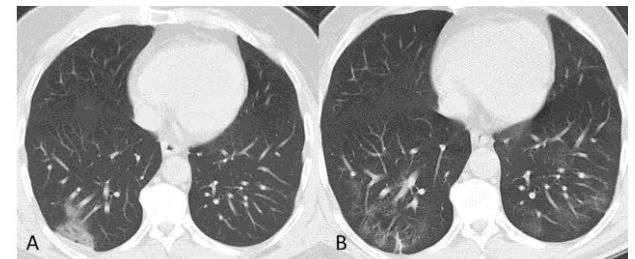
A 50-year-old male patient who presented with cough and fever had a peripheral consolidation area in the lower lobe of the right lung on the chest CT performed 2 days after the onset of symptoms (A). The CT of the same patient performed 30 days after the first CT showed regression in the consolidation visualized in the right lung, and a fibrotic band at this level. In addition, areas of obliterated GGO density, which were not visualized on the first CT, were noted in the lower lobes of both lungs (B).
